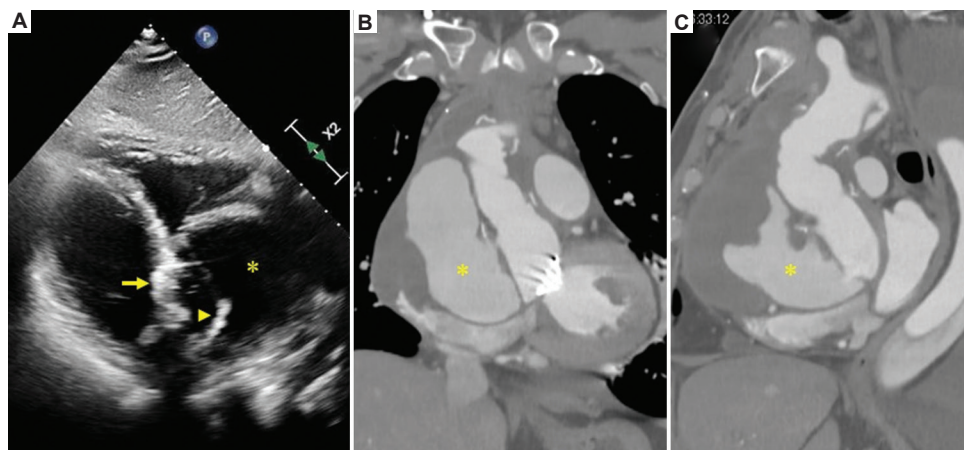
(A) Transthoracic echocardiography shows a markedly dilated aortic root (asterisk) with normally functioning mechanical valve (arrow). A hyperechoic line (arrowhead), suggestive of the polyester fabric sheet from the previous operation, is visible. Computed tomography reveals a large pseudoaneurysm (asterisk) in the coronal (B) and the sagittal (C) views.
